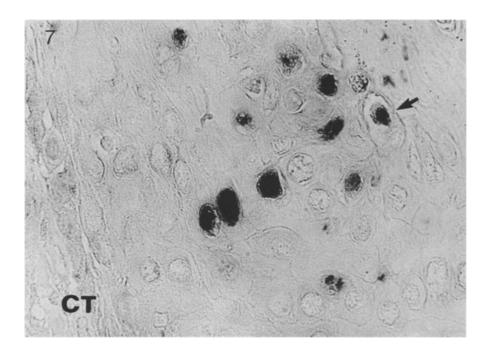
Same case as in Fig. 6. Invasive front of the tumour (CT = connective tissue-tumour-interface). Polymorphous and in part dyskeratotic (arrow) keratinocytes with nuclear hybridization. Mag. × 500
